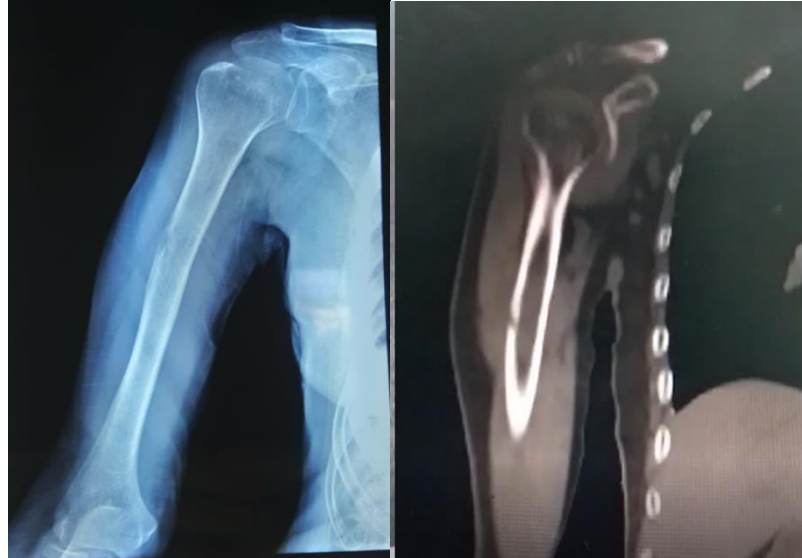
48-years-old female, right humerus showed a small lytic lesion of the external cortex of shaft without a periosteal reaction. The CT revealed the same lesion with no soft tissue extension and a bone biopsy, the IHC results in favor of diffuse large B cell lymphoma.
